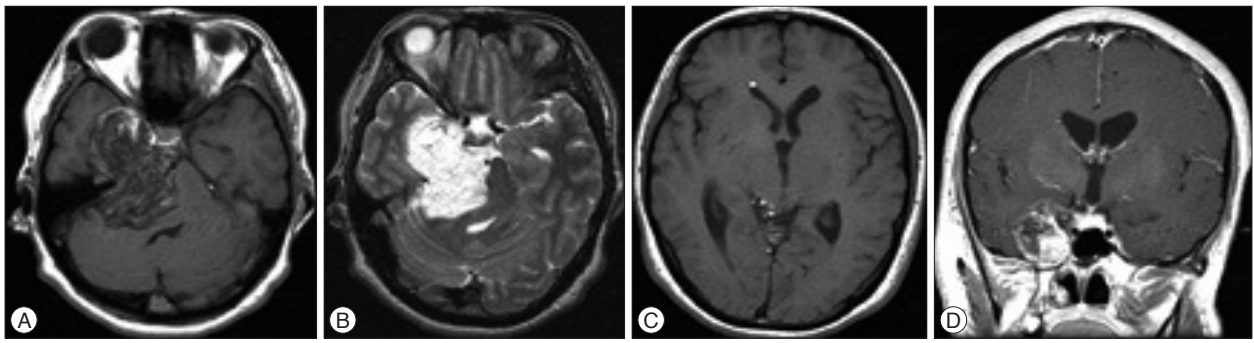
Preoperative brain magnetic resonance (MR) images. A : Axial T1-weighted MR image reveals a hypointense tumor with partially mixed signal intensity in the right middle and posterior fossa of the skull. B : Axial T2-weighted MR image shows a hyperintense tumor in the skull base including cavernous sinus. C : Axial T1-weighted MR image demonstrates multiple hyperintense lesions in the right lateral ventricle and basal cisterns suggesting the content of cystic rupture. D : Coronal T1-weighted enhanced MR image shows an enhanced tumor in the right cavernous sinus and temporal base.
